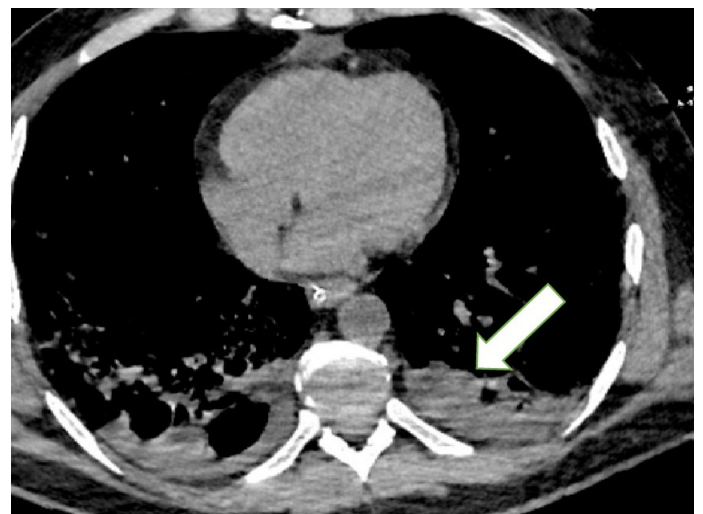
60-year-old man with laboratory confirmed coronavirus disease (Covid-19). Patient presented with dyspnea for two days. Bilateral pleural effusion is seen on axial CT image (arrow).
